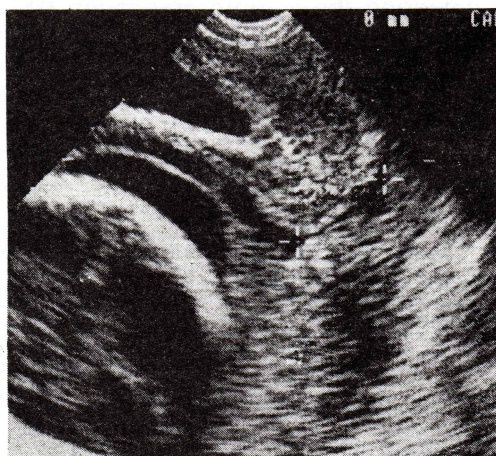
Transvaginal sonography demonstrating posterior placenta previa.
